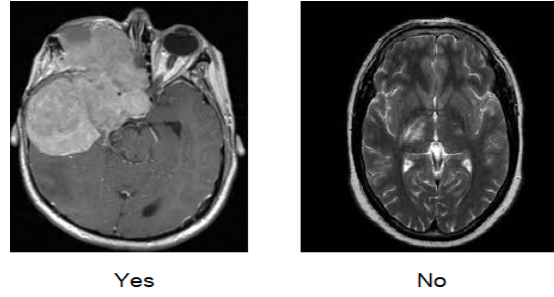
Brain Magnetic Resonance Image
